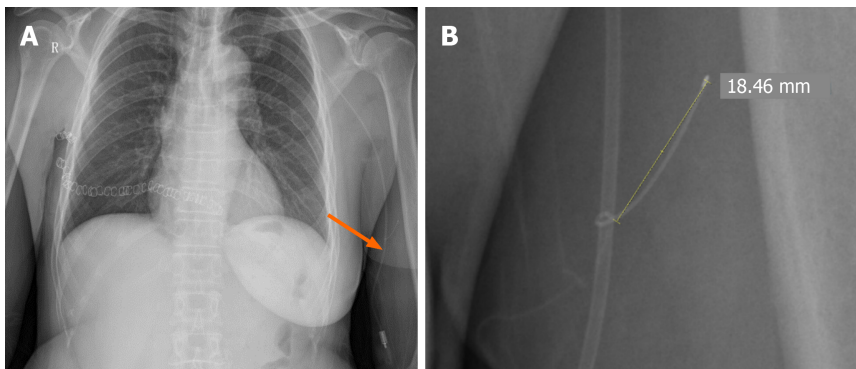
X-ray imaging results. A: The postoperative X-ray images indicated that the peripherally inserted central catheter was positioned correctly at the T7 cone space level on the right side; B: The postoperative X-ray images revealed that an unusual guide wire measuring around 1.8 cm in length was detectable above the left elbow.
